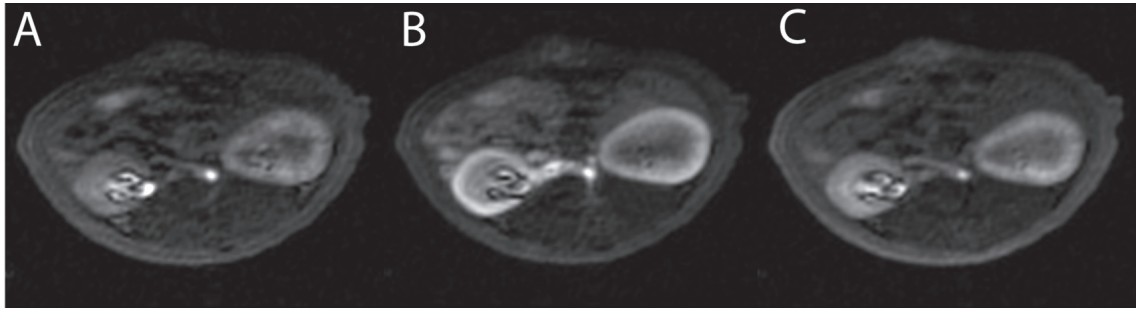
Representative DCE-MRI images at different time points. (A) Baseline image before contrast agent injection. (B) Cortical peak contrast image approximately 40 s after bolus injection and an image (C) taken approximately 4 min later showing increased medullar contrast. Regarding the contrast uptake and its distribution, the AKI kidney (right kidney in the image) can clearly be distinguished from the healthy kidney. Image taken from Zimmer et al. [2013].*
